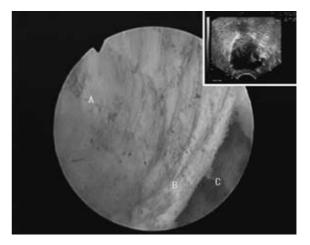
Smooth and fine granular surface in margin of an adenoma, false capsule after false complete resection with TURP, the detached surgical capsule with TUE, and transrectal ultrasound image on upper right. A: margin of adenoma similar to the outer gland. B: false capsule. C: exposed surgical capsule with detaching blade
